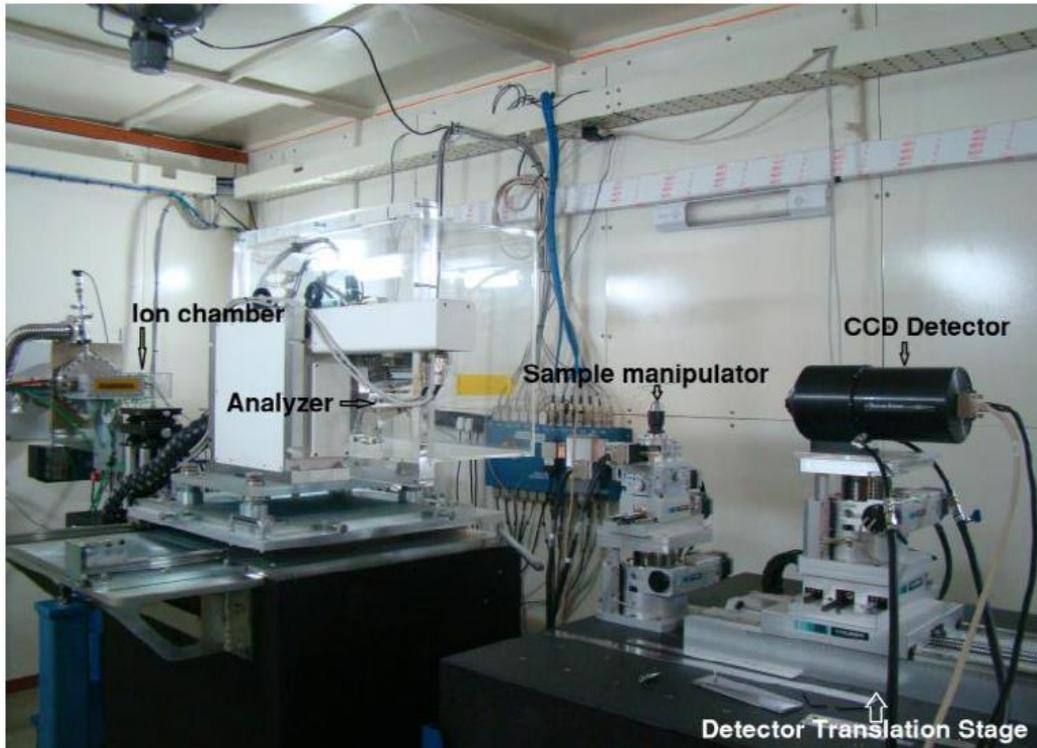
Synchrotron x-ray imaging beam line (BL-4) facility at Indus-2, RRCAT, Indore, India
